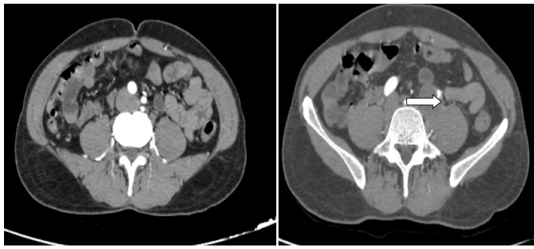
CT angio images showing narrowing of left common iliac artery distally
